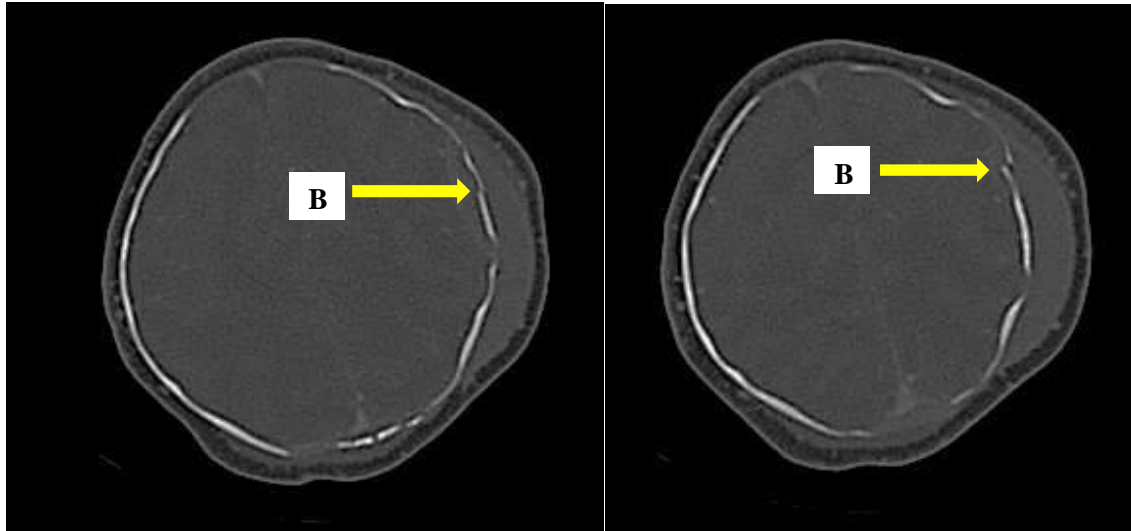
Axial Contrast CT bone window showing the depressed skull fracture Arrow B
